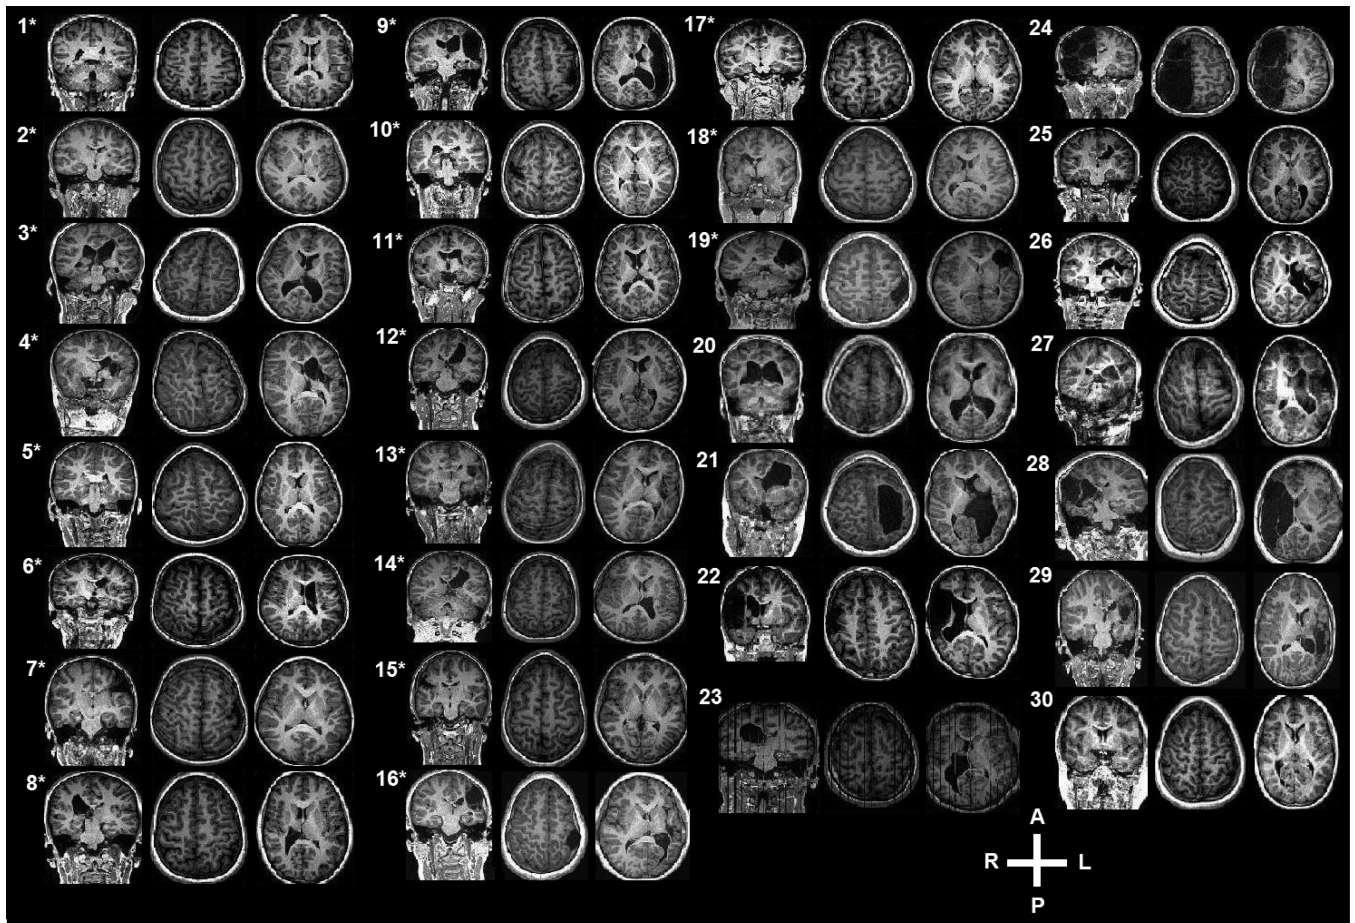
One coronal and two transverse views of anatomical magnetic resonance images depicting damage to primary motor cortex and/or posterior limb of internal capsule of participants with an ipsilesional primary motor cortex motor-evoked potential (denoted by asterisk) and those participants without a motor-evoked potential.
